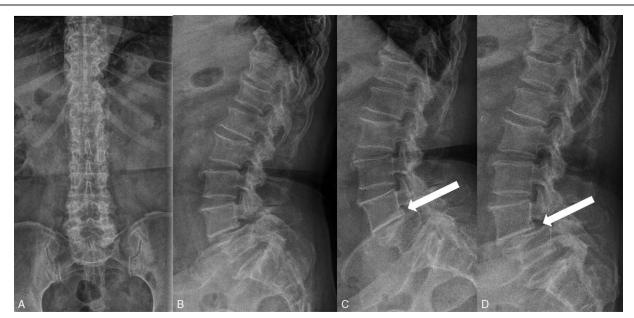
Preoperative plain anteroposterior (A), lateral (B), extension (C), flexion (D) radiograph views of the lumbar spine showing L4–5 spondylolisthesis and disc space narrowing (arrow).
